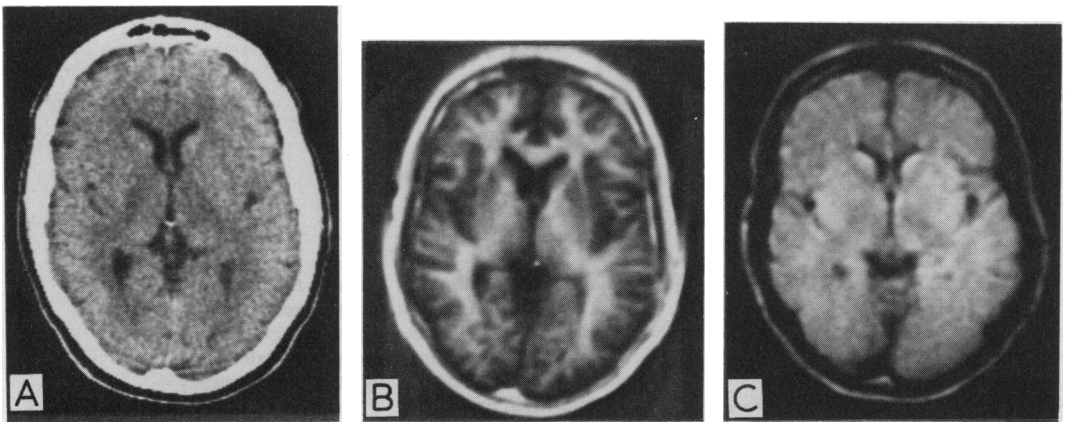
Comparable CT (A), T_1 (B) and T_2 (C) scans of the normal brain at low ventricular level. The T_1 image shows clear grey-white matter differentiation. The inner and outer tables of the skull give a low signal and appear dark, but subcutaneous fat and bone marrow appear light. The T_2 image shows less anatomical detail
